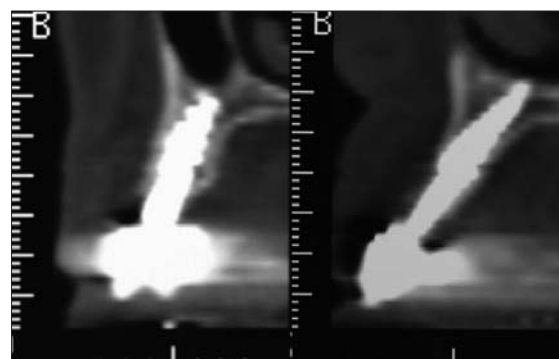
CT scan after 20 months, cross reconstructions; multicorticalism guarantees stability, a basic requirement of the immediate load technique, and is one of its key success factors.
